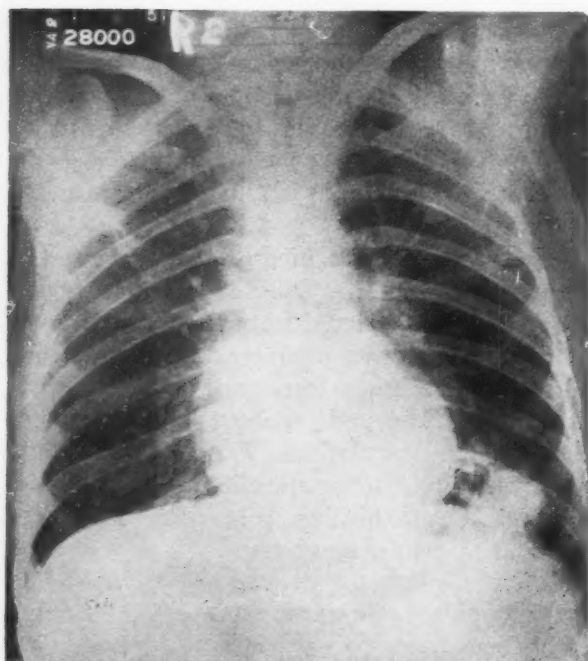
Preoperative anteroposterior roentgenogram of chest of patient described in this paper.
